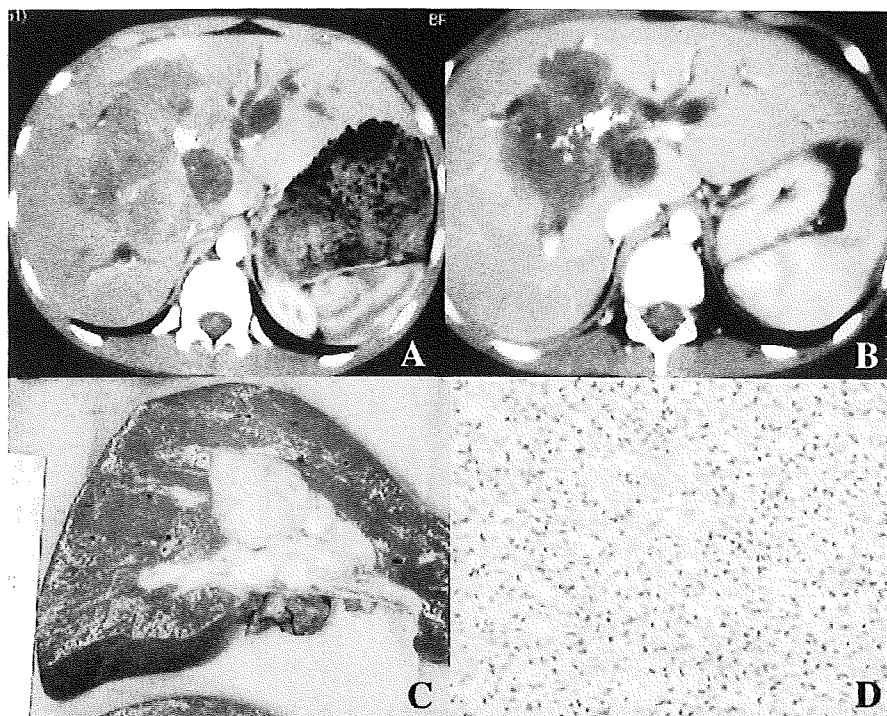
A, Enhanced abdominal CT scan before chemotherapy shows a large heterogeneous low-density mass occupying the hilar region of the liver. B, Follow-up CT scan after one cycle of chemotherapy shows a marked reduction in the size of the primary tumor; however, it still occupies the hilum of the liver. C, A solitary stromal tumor is seen at the hilar region of the explanted liver. D, Diffuse proliferation with immature spindle cells.
